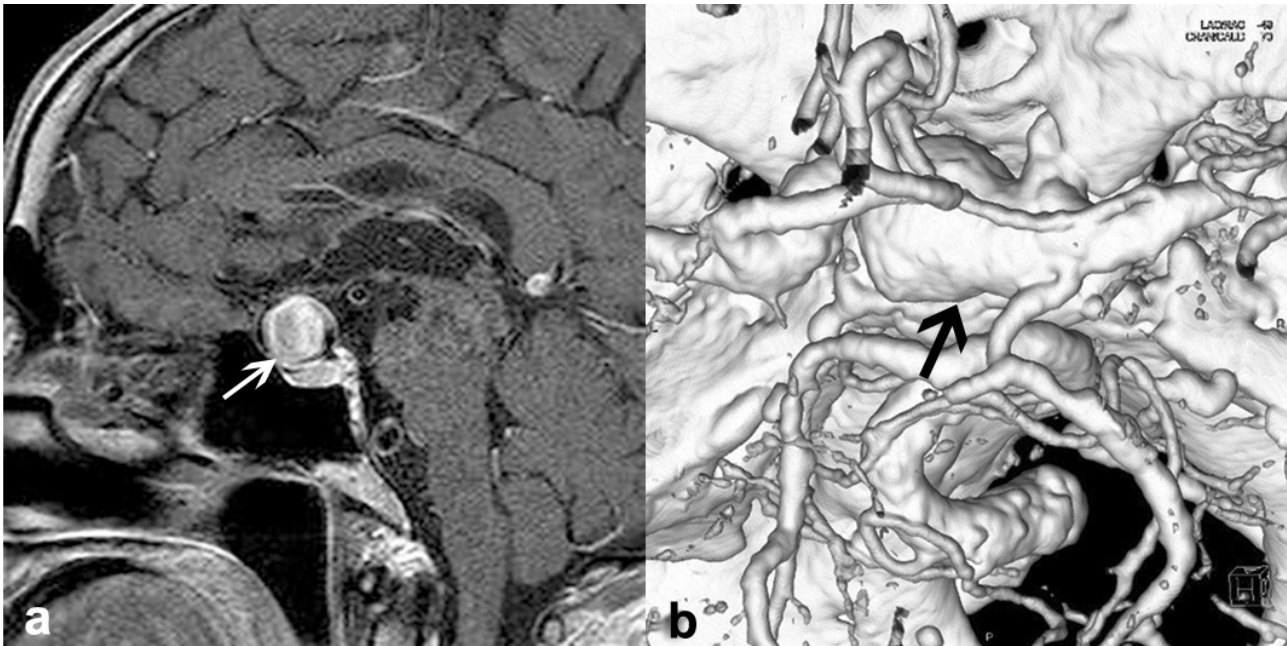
Pre-treatment magnetic resonance imaging (MRI) and computed tomography (CT) angiography of the aneurysm. MRI T1-weighted sequences mid-sagittal section with contrast (a) shows a large intrasellar lesion (white arrow) with an unusual pattern of enhancement, which is different from a pituitary adenoma and necessary for further investigation for an aneurysm. CT angiography 3D reconstruction (b) demonstrates a large right supraclinoid ICA aneurysm (black arrow) extending into the sellar region.
